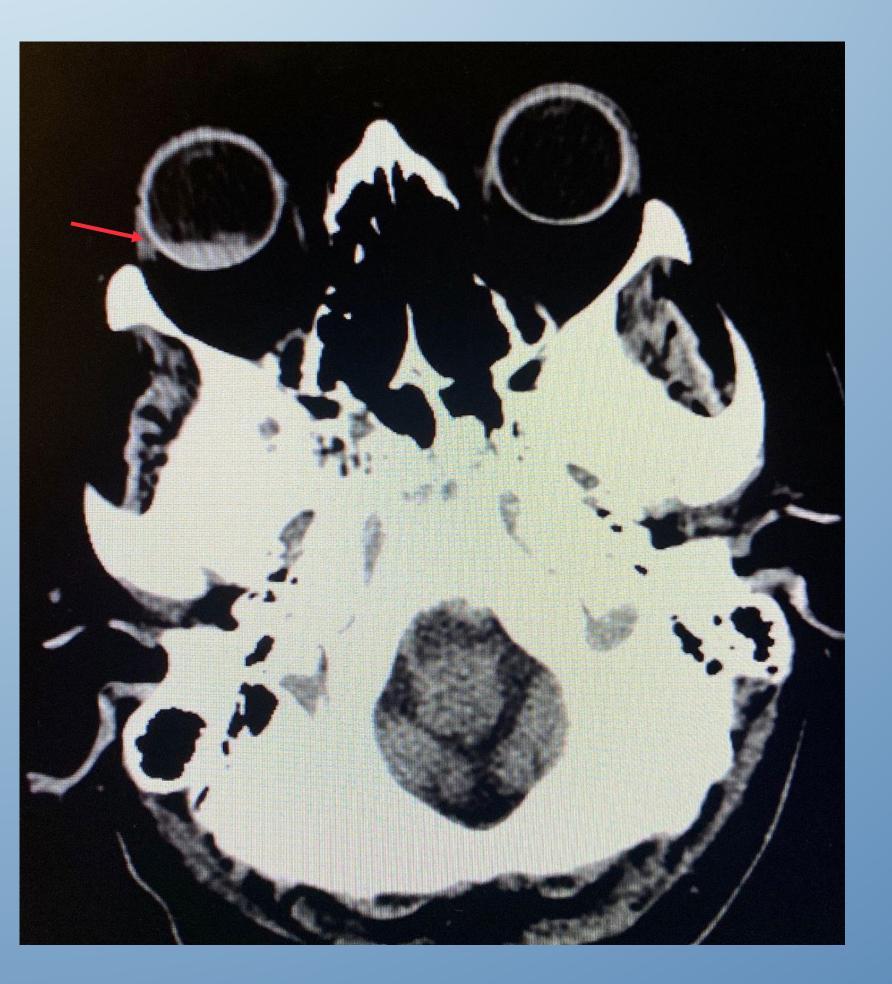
A CT scan of the head 16 hours after t-PA administration when patient began complaining of vision loss. Red arrow indicating hemorrhage in the posterior of the right globe.
